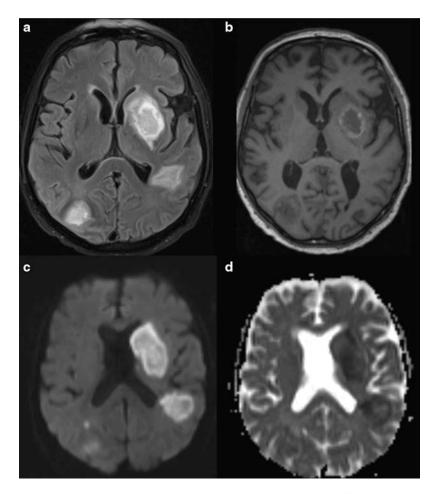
Invasive aspergillosis of the brain in a 70year-old male patient with lung carcinoma and chemotherapy. (a) Axial T2 tirm MR image shows bihemispheric hyperintense lesions. (b) Unenhanced axial T1 weighted MR image shows bihemispheric hypointense lesions with a rim of high signal intensity representing
